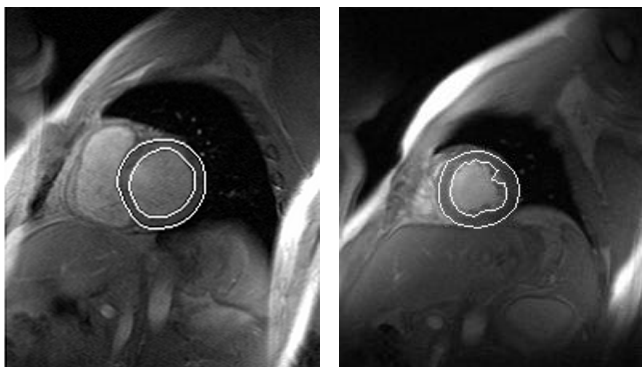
Examples of automated delineation of the endo- and epicardial contours of the left ventricle in a single slice of short-axis cardiac MRI. Each image shows the right ventricle to the left of the contours and the dark region to the right is the lung.
